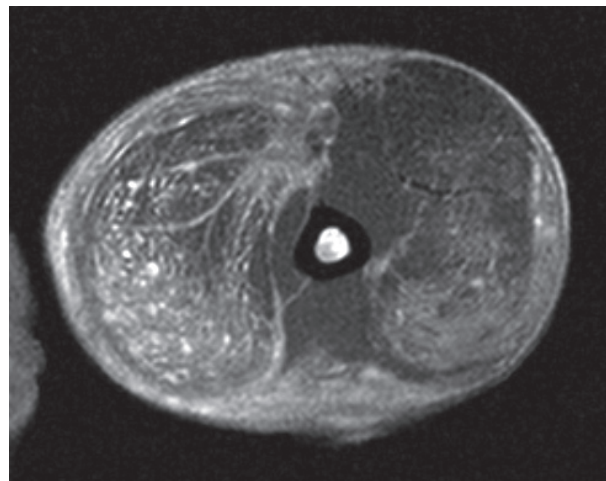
Cross-sectional magnetic resonance image of the upper right arm approximately one month after the last oil injection, showing illuminated, confluent and small, cystic areas representing paraffin oil.
